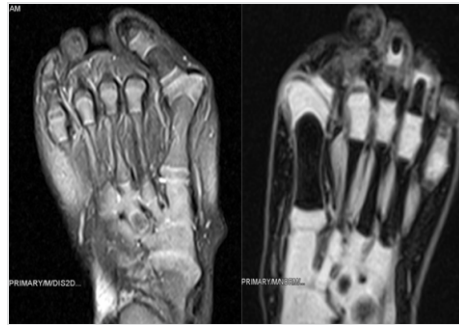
Coronal magnetic resonance imaging of the feet at 6 months of age revealed a broad, cartilaginous component of the distal first metatarsal, suggestive of incomplete preaxial polydactyly without a supernumerary digit.
